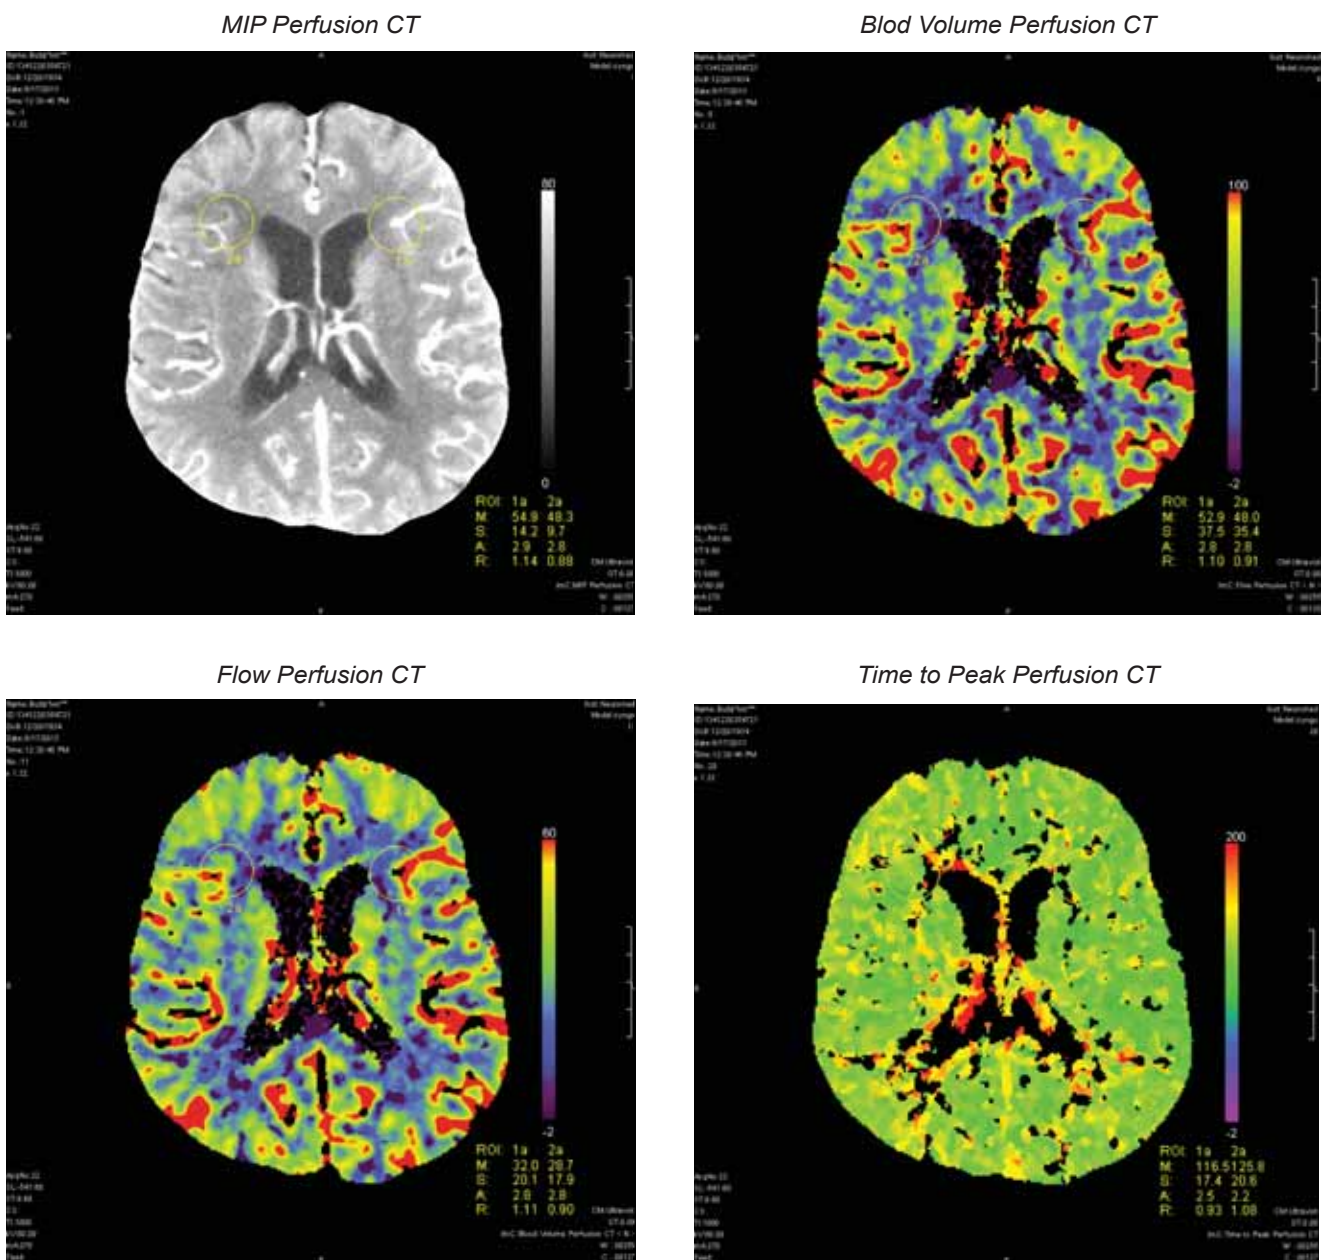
CT perfusion highlighted by the MIP image and of the and the sum of CBF, CBV, TP in the two areas 1a, 2a examined by highlighting the hypoperfusion in area 2
